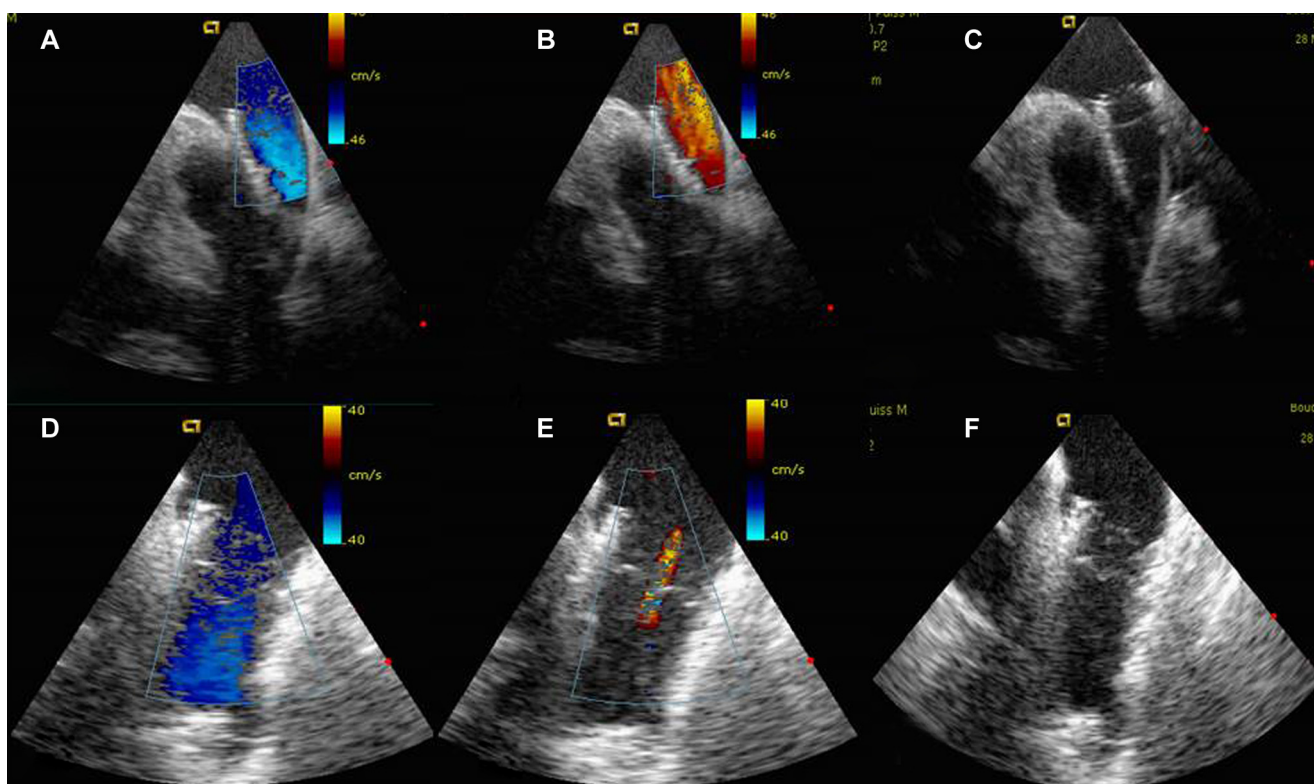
Still-frame echocardiographic images from patient with redo Melody valve following the jailing technique. A. Colour Doppler image showing unrestrictive forward flow through the Melody valve. B. Colour Doppler image during diastole showing free regurgitation; note the absence of paraprosthetic leak. C. Image showing Melody valve; no valve leaflet could be found (the disappearance of the leaflets explains the free regurgitation). D–F. Echocardiographic images obtained after redo Melody valve: unrestrictive forward flow (D); tiny central regurgitation (E); visualization of coapting leaflets of the new Melody valve (F).
